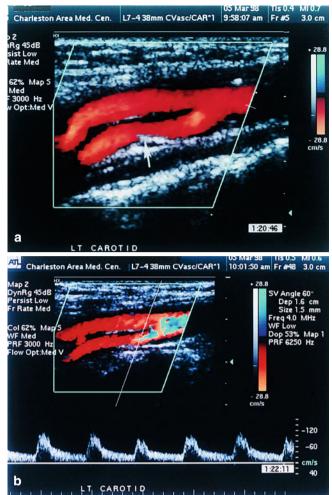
(a) A color duplex ultrasound image showing mild plaquing (15–<50% stenosis) of the internal carotid artery (*arrow*). (b) The same patient in (a) showing internal carotid artery Doppler spectra associated with mild stenosis
